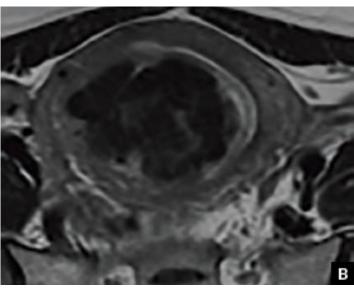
Pelvic MRI scans of uterine fibroids
